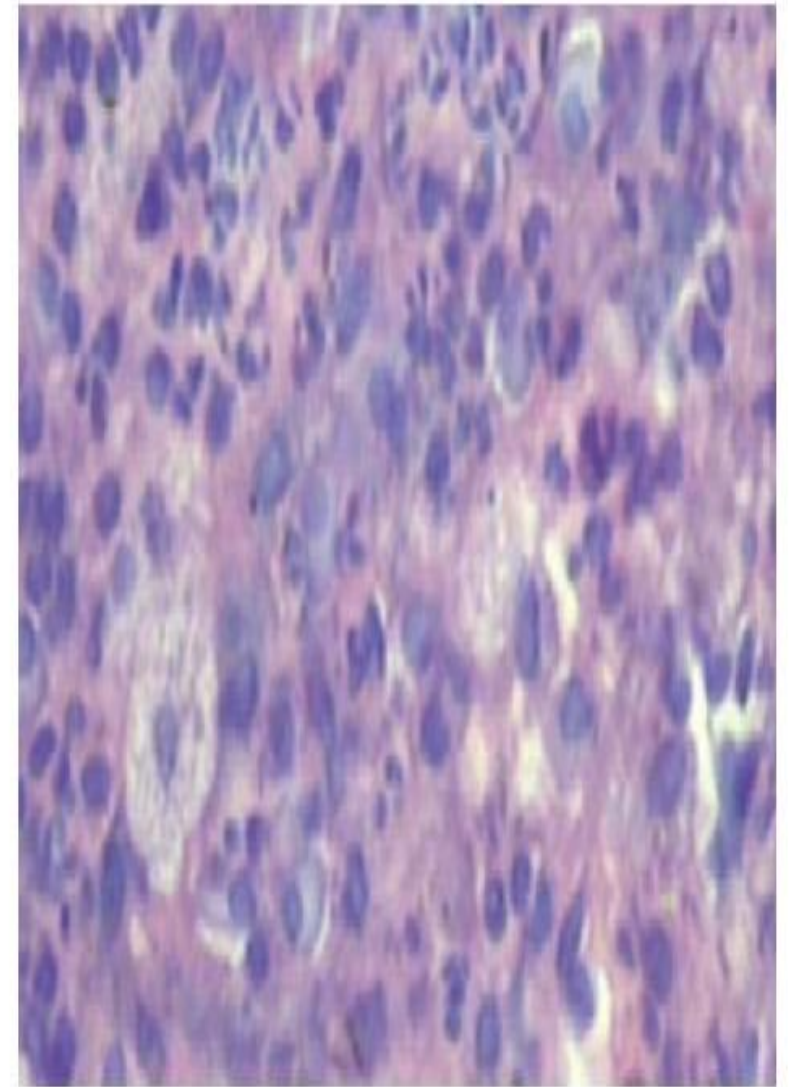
Periapical abscess
